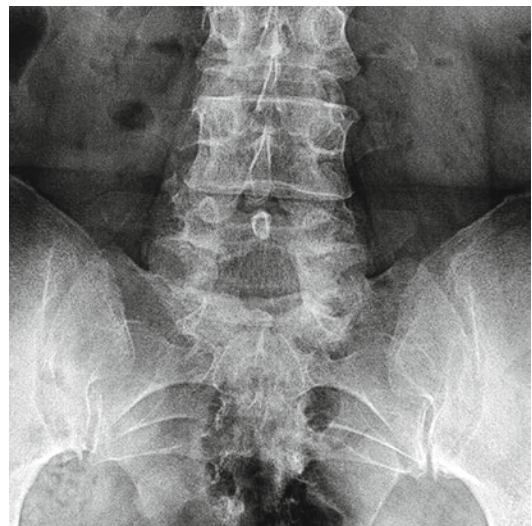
Anteroposterior lumbar radiograph
